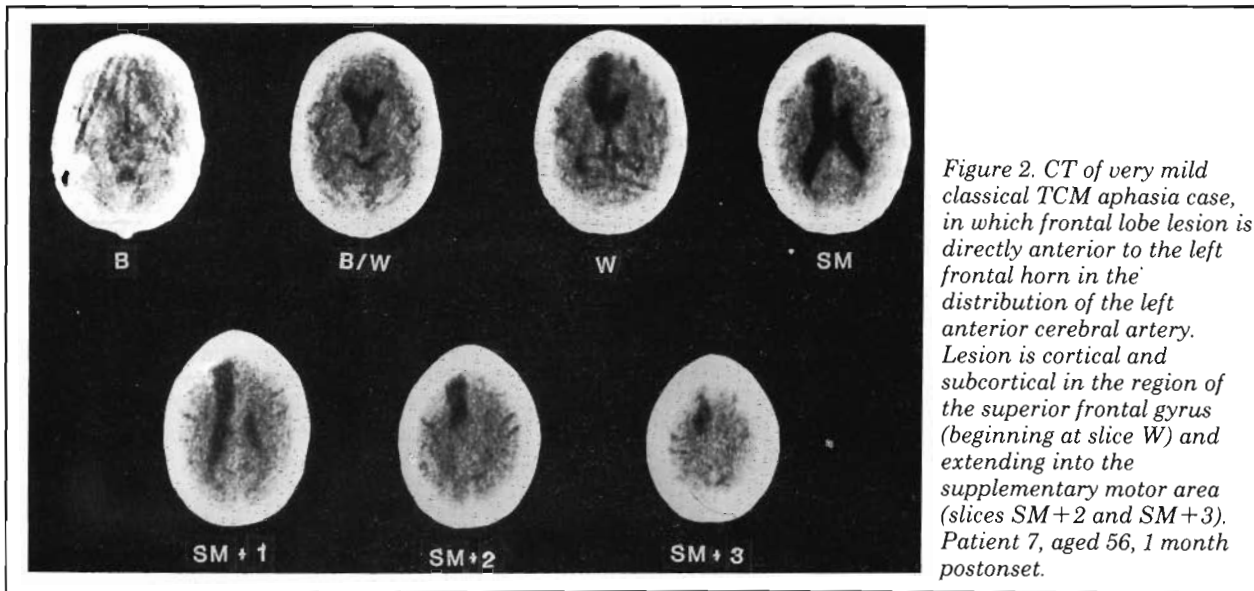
CT of very mild classical TCM aphasia case, in which frontal lobe lesion is directly anterior to the left frontal horn in the distribution of the left anterior cerebral artery. Lesion is cortical and subcortical in the region of the superior frontal gyrus (beginning at slice W) and extending into the supplementary motor area (slices SM+2 and SM+3). Patient 7, aged 56, 1 month postonset.
